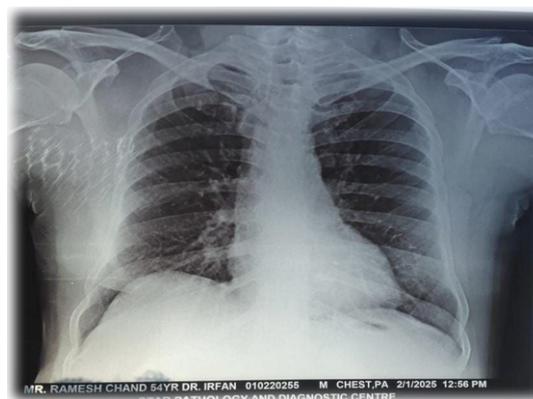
Radiological evaluations using X-rays
